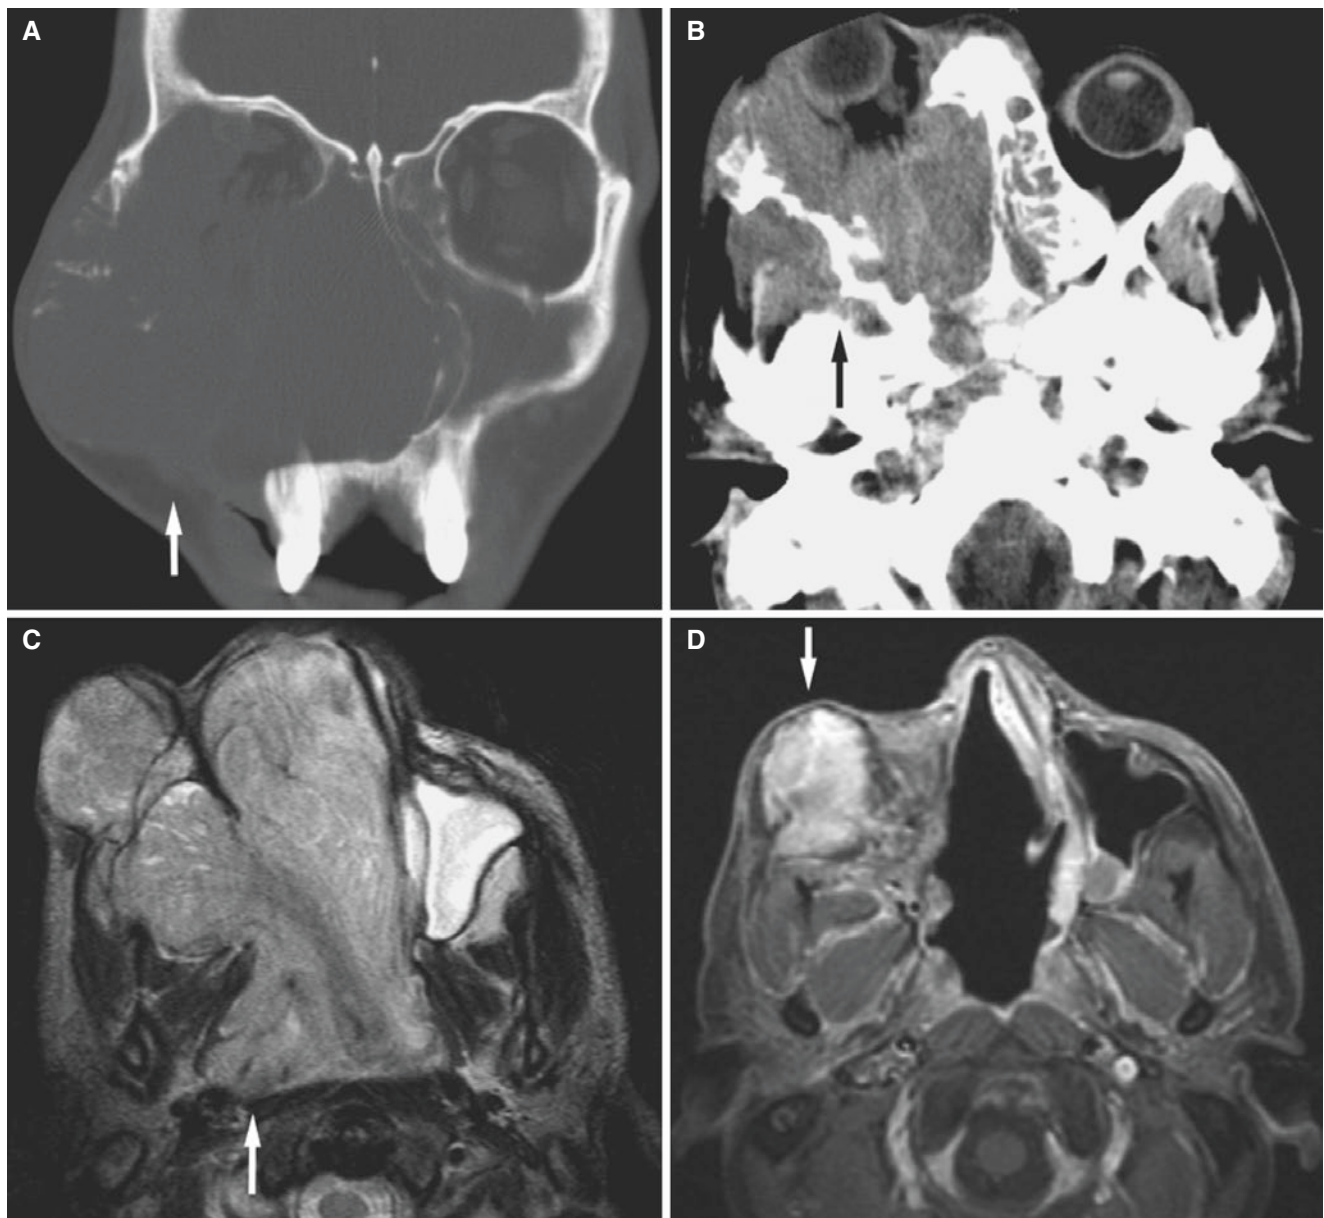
Maxillary Ewing sarcoma; 30-year-old male with huge facial mass, proptosis, shortness of breath, and dysphasia. (A) Coronal CT image shows enormous tumor (*arrow*) with destruction of the maxilla, zygoma, orbital floor, and nasal cavity, crossing the midline with expanding medial wall of the left maxillary sinus. (B) Axial CT image shows the huge destruction and displacement of the right globe (*arrow*). (C) Axial T2-weighted fat-suppressed MRI shows the huge exophytic
